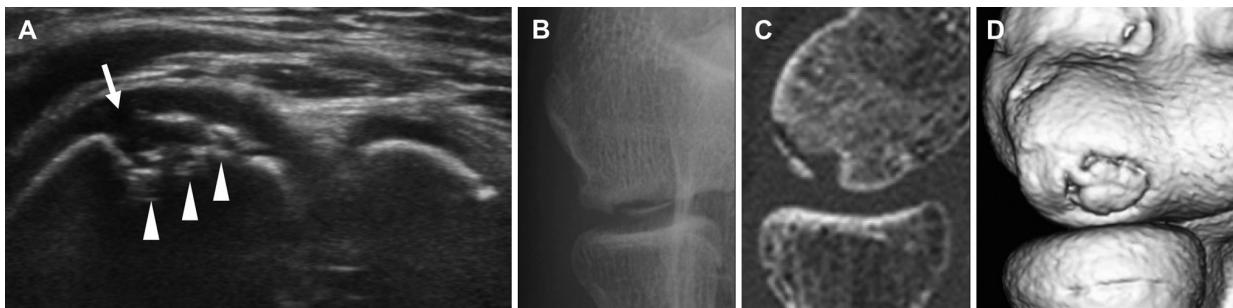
Stage II (fragmentation stage) osteochondritis dissecans of the humeral capitellum (nondisplaced fragments). (A) Ultrasonographic image taken during the initial screening (posterior long-axis view). A break in continuity of the echo line (arrow) and a double floor line (arrowheads) was observed on the capitellum. (B) Radiograph (45° flexed tangential anteroposterior view) obtained at the initial examination. (C) Sagittal slice of the humeral capitellum by computed tomography. (D) Anterior view of the 3-dimensional computed tomography.
